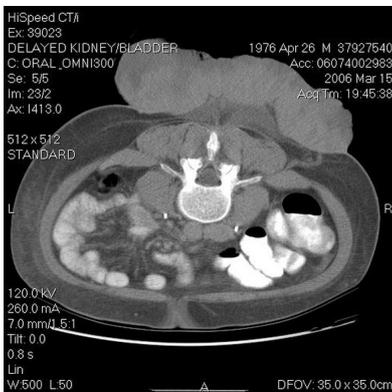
CT image shows mass extension into subcutaneous tissues
